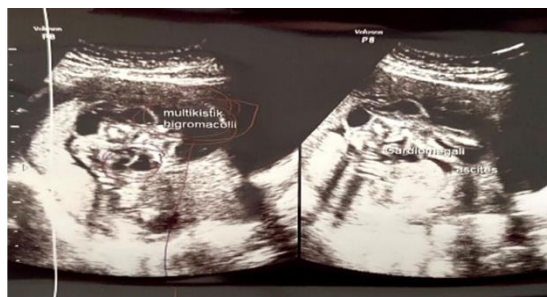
Fetomaternal ultrasound at 19+4 weeks of gestational age
